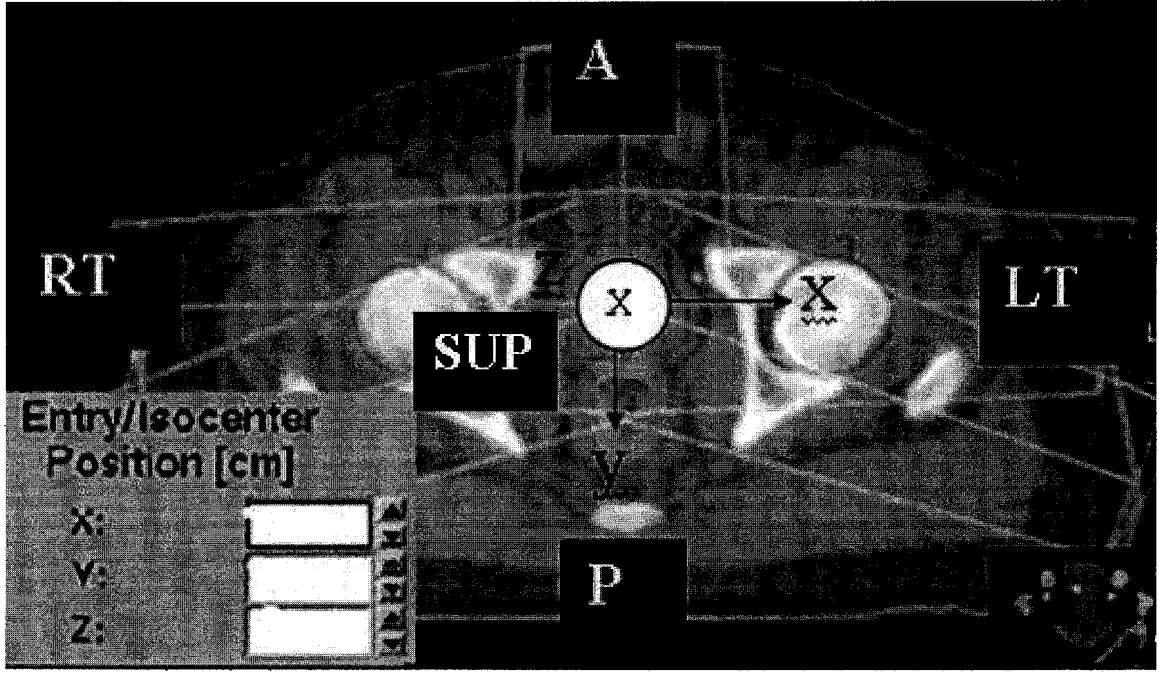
CADPLAN CT axial slice of a patient, the panel to enter the isocenter position and two coordinate system conventions: CADPLAN (x,y and z) and patient anatomy (A/P, RT/LT and SUP/INF).
